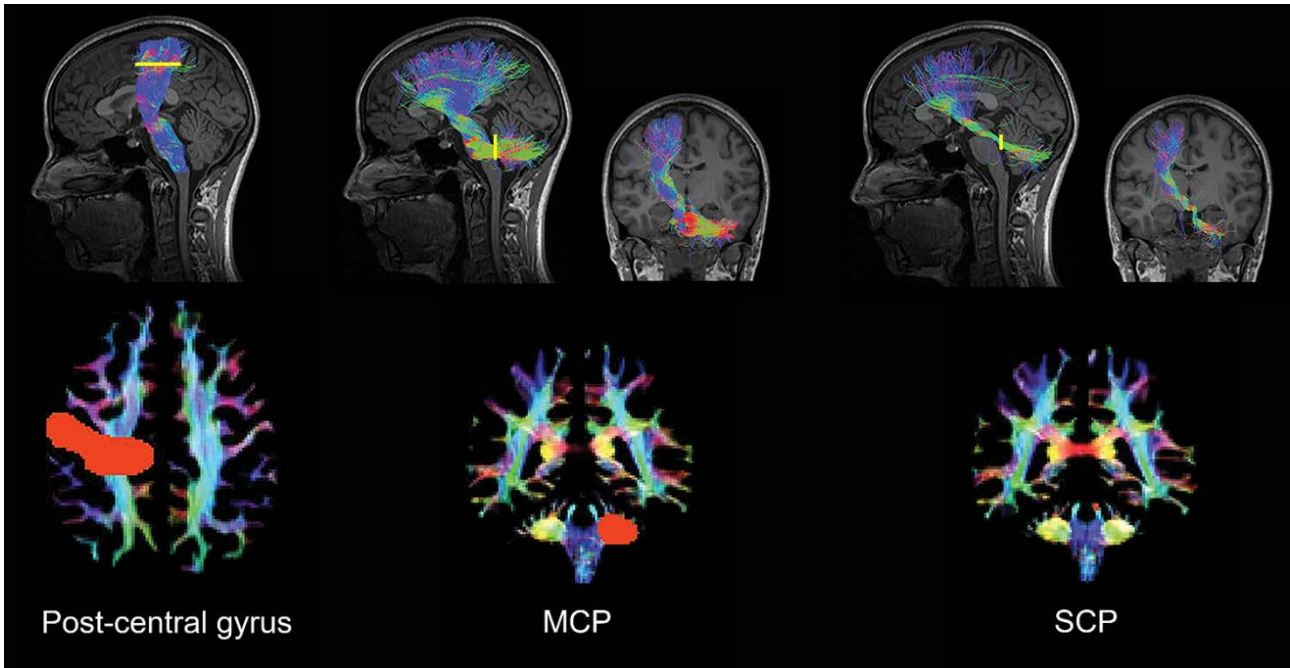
First row: Tractography of white matter (WM) corticospinal (left) and corticomotor-cerebellar (middle and right) tracts from a typically developing control subject in the sagittal T1-weighted image. Coronal images (middle and right) show decussation of corticomotor-cerebellar tracts. Yellow lines indicate corresponding region of interest (ROI) placement. Second row: ROI selection of the postcentral gyrus (left), medial cerebellar peduncle (MCP; middle) and superior cerebellar peduncle (SCP; right) marked on a directionally encoded colour fractional anisotropy (decFA) image in the axial (left) and coronal (middle and right) planes, respectively. The decFA colour scheme is represented as follows: red (left-right fibre orientation), blue (inferior-superior fibre orientation) and green (anterior-posterior fibre orientation).
